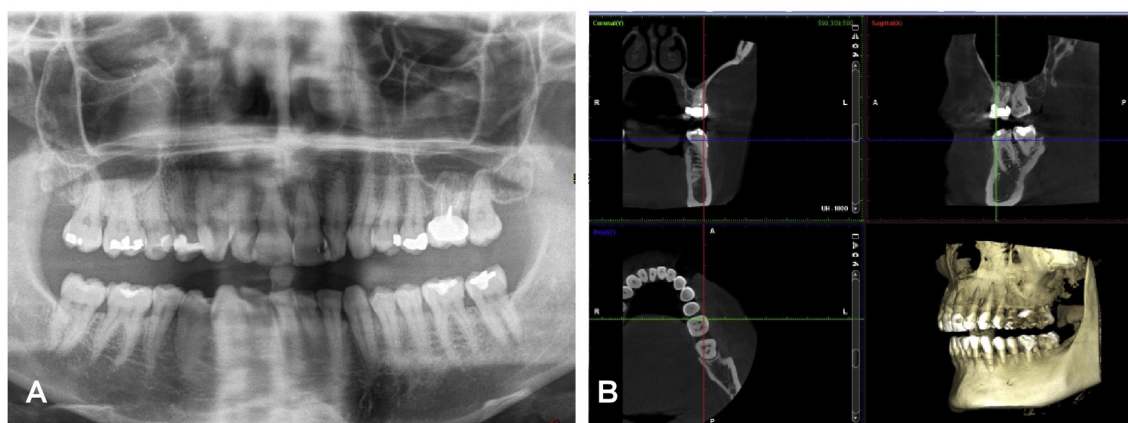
Imaging techniques during acute infective endocarditis. A. Initial panoramic X-ray showing doubtful radiolucency involving the apex of the maxillary left molar. B. Observation of the lesion with three-dimensional cone beam computed tomography imaging, confirming periapical lesions of the maxillary left molar and showing additional bone destruction.
